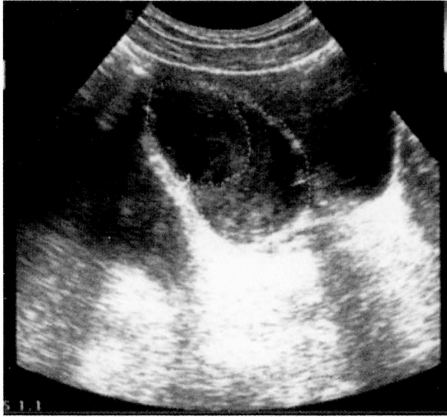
Ultrasonographic appearance of appendiceal mucocele (transvaginal examination).
